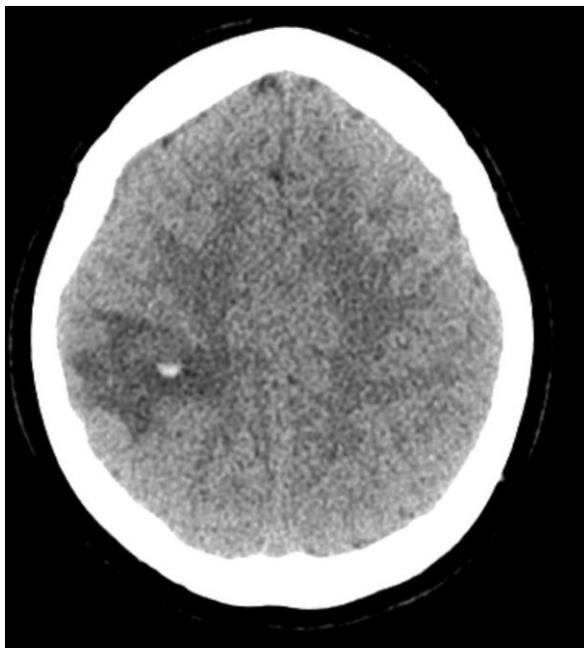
Axial CT showing a parenchymal focal 6mm hemorrhage w/ hyperdense region in the frontoparietal area with surrounding vasogenic edema.
